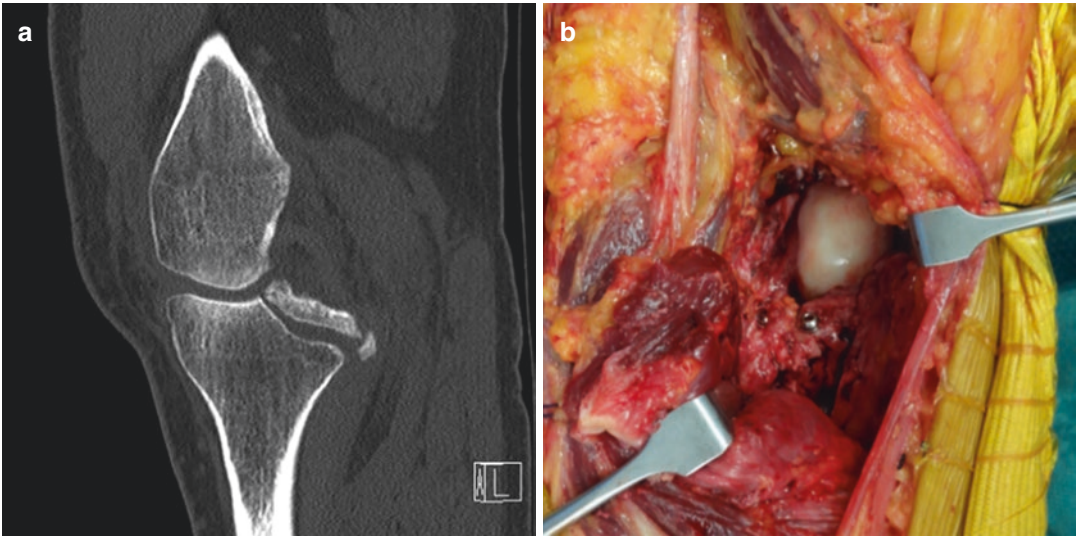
(a) CT scan showing non-union of a PCL avulsion fracture. (b) Intra-operative photo of a posterior approach to the knee and screw fixation of the PCL avulsion fracture
